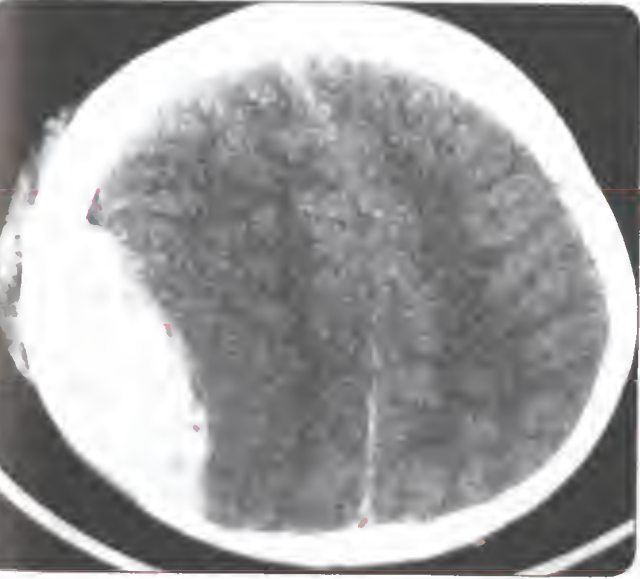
CT scan head showing extradural hematoma with biconvex lesion
